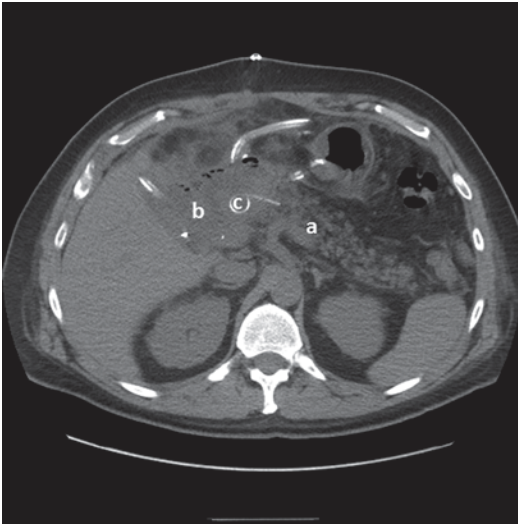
Computed tomography scan showing pancreaticojejunostomy leak. a - pancreatic remnant, b - peripancreatic fluid collection, c - pancreatic duct stent
